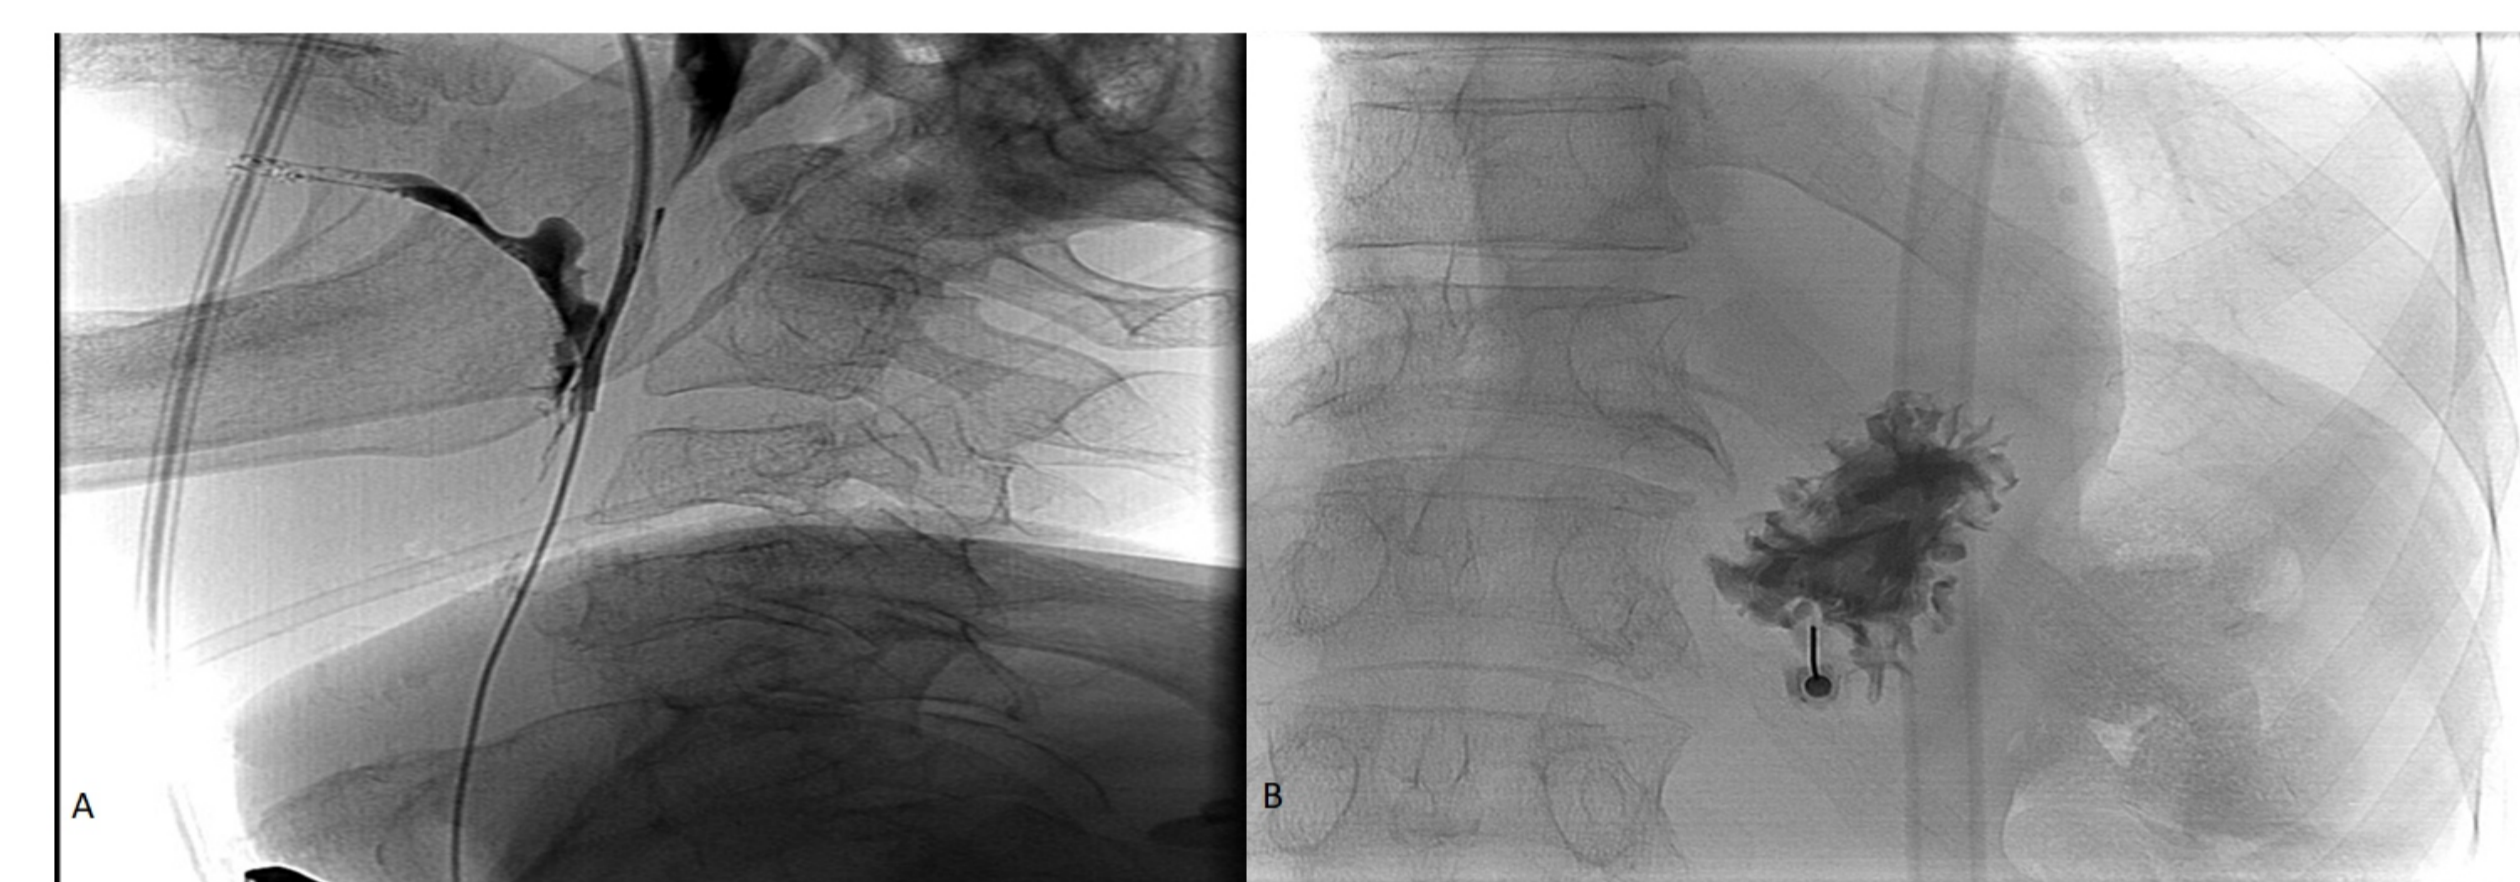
Direct stomach access. (A) Oropharyngeal stricture blocking the angiographic catheter progression. (B) Gastric puncture was performed under ultrasonographic guidance.
